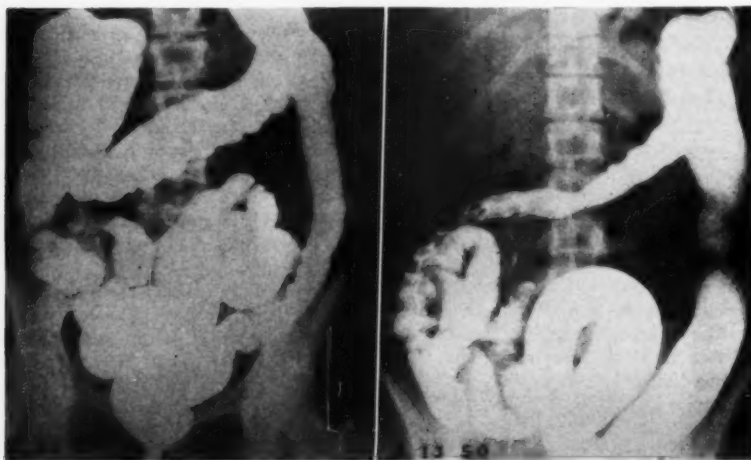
M. C. S. Persistent roentgen evidence of ulcerative colitis. Complete clinical recovery.
